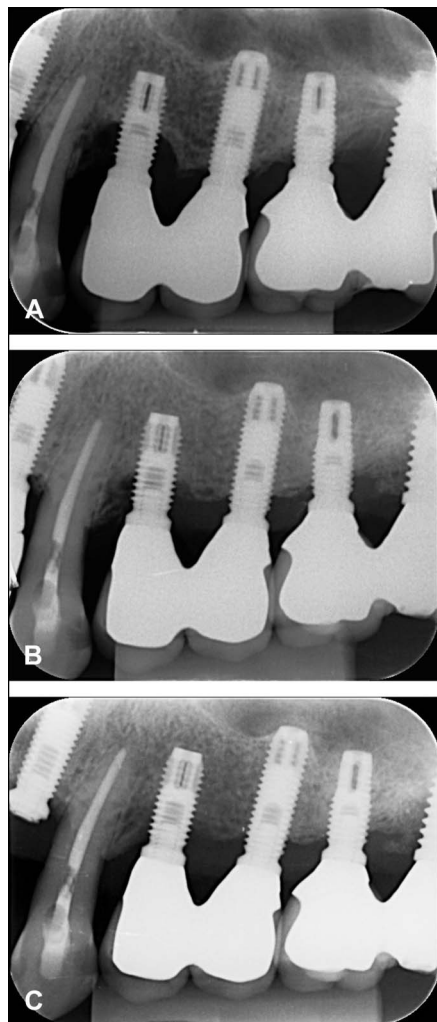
Comparison among initial (A), 6-month (B), and 30-month (C) periapical radiographs showing significant bone fill around the previously exposed threads of the implant 24 and stabilization of the marginal bone.
